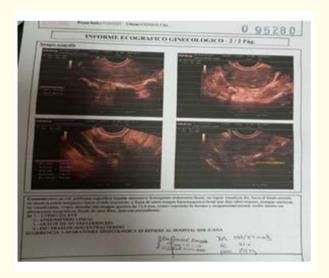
Ultrasound report, without evidence of IUD in the uterine cavity and location not specified.
